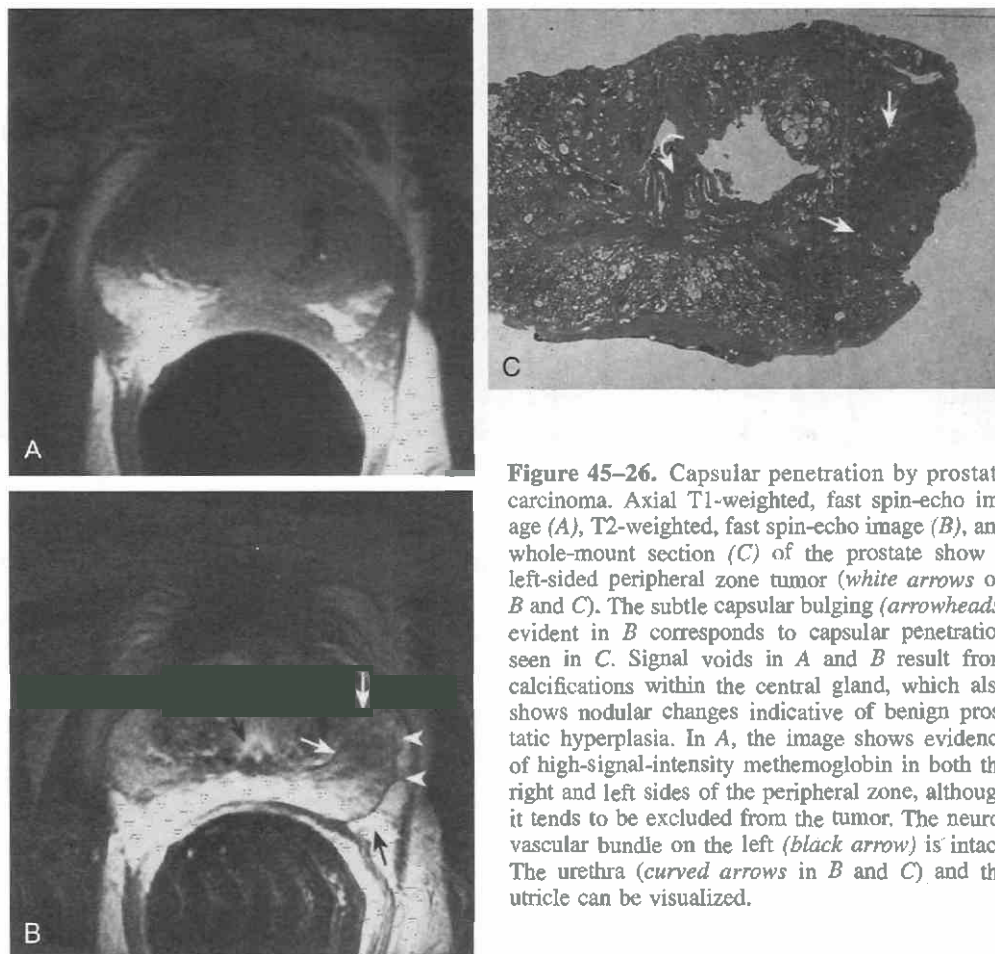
Capsular penetration by prostate carcinoma. Axial T1-weighted, fast spin-echo image (A), T2-weighted, fast spin-echo image (B), and whole-mount section (C) of the prostate show a left-sided peripheral zone tumor (white arrows on B and C). The subtle capsular bulging (arrowheads) evident in B corresponds to capsular penetration seen in C. Signal voids in A and B result from calcifications within the central gland, which also shows nodular changes indicative of benign prostatic hyperplasia. In A, the image shows evidence of high-signal-intensity methemoglobin in both the right and left sides of the peripheral zone, although it tends to be excluded from the tumor. The neurovascular bundle on the left (black arrow) is intact. The urethra (curved arrows in B and C) and the utricle can be visualized.
